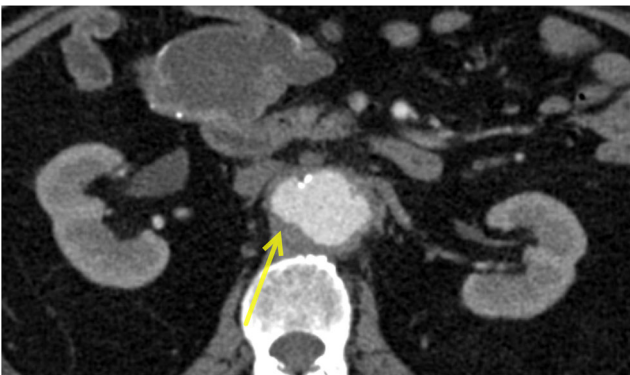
Transverse CT image showing an outpouching of the right lateral aspect of the abdominal aorta with inflammatory thickening of the aortic wall (*arrow*); this is a surgically proven mycotic aneurysm and should not be confused for a fistula as the inflammation is centered in the aortic wall
